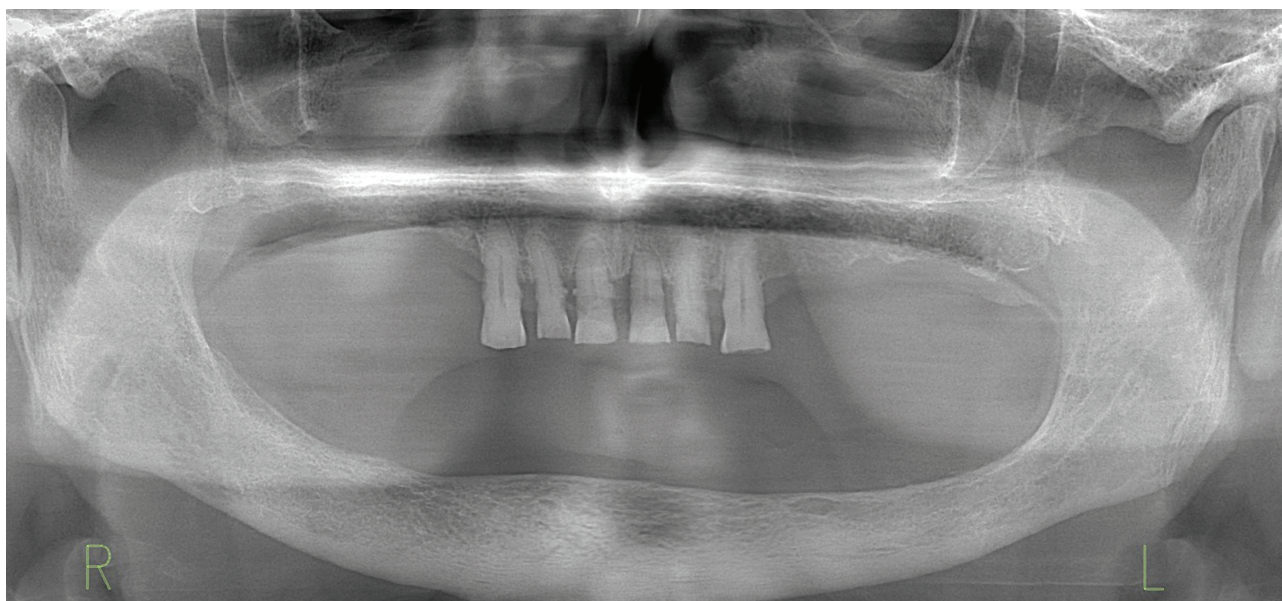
OPG x-ray of a patient with DM and CKD. The patient lost his teeth due to periodontitis.
